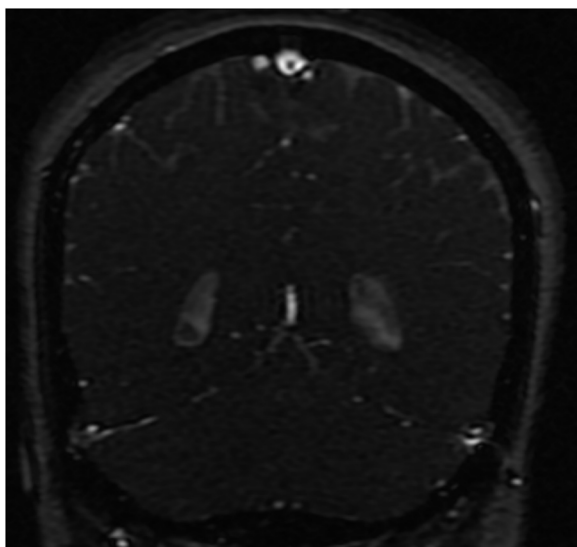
Pre-decompression coronal 2D time of flight MR image showing diminished size of the transvers sinuses bilaterally. This is a finding frequently associated with elevated intracranial pressures.
